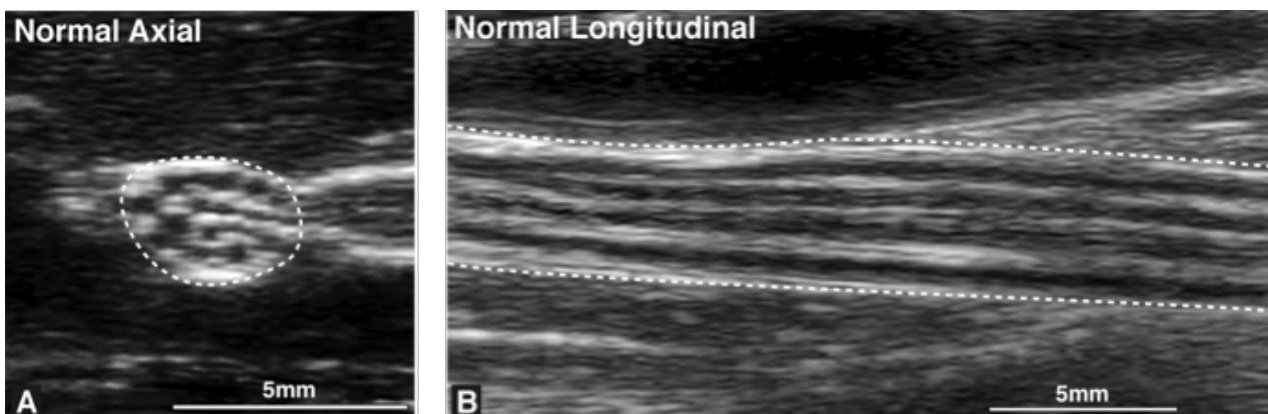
Ultrasound of normal nerve showing a honeycomb pattern on cross-sectional imaging (A) and the nerve fascicles running through the nerve on longitudinal imaging (B).
